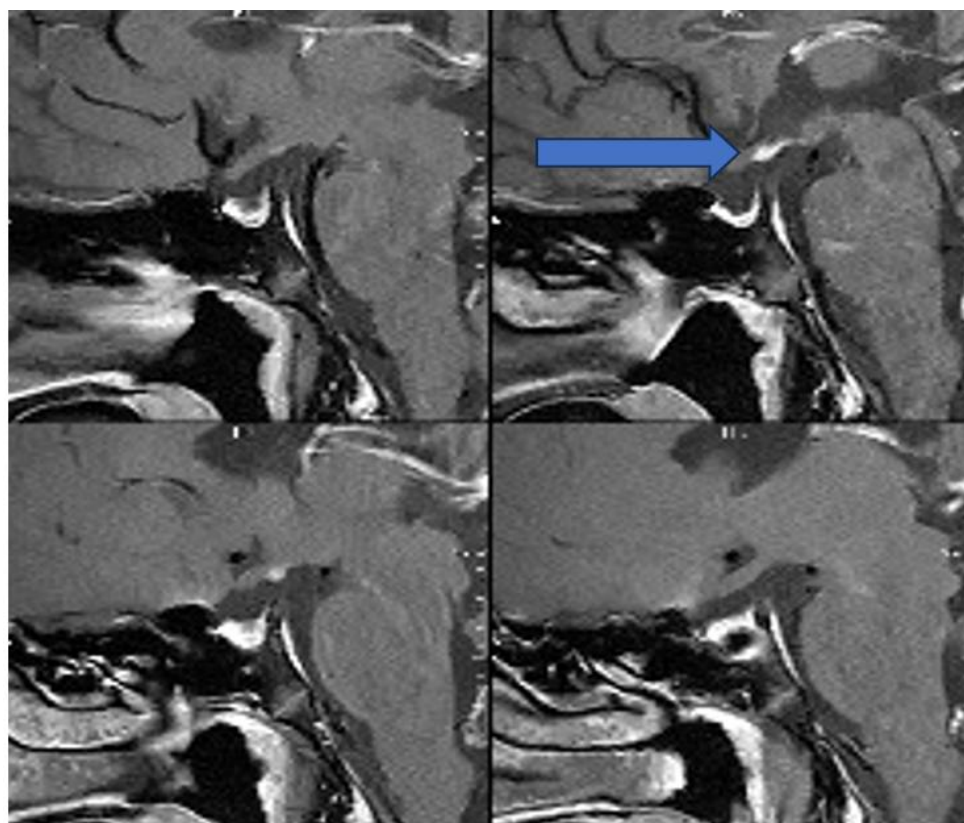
Contrast enhanced MRI demonstrating an ectopic posterior pituitary bright spot.
